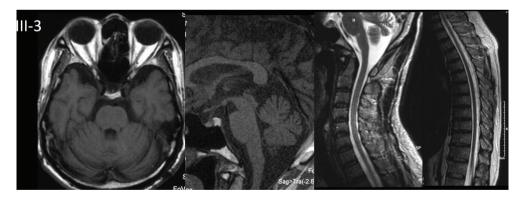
Brain and spinal MRI of the patient III-3. The brain MRI showed mild cerebellar atrophy, and spinal MRI disclosed mild thoracic cord atrophy.
